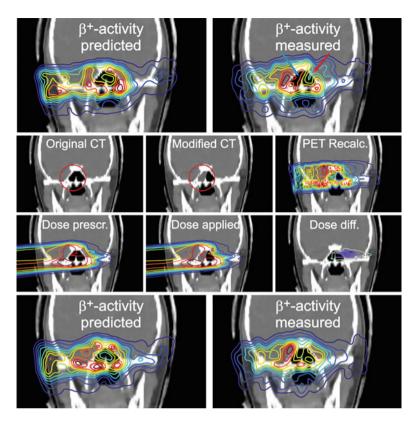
Anatomical changes, their effects on dose and the approximate quantification of dose deviations from the treatment plan. *First row*: Comparison of predicted and measured β^+ -activity. The *blue arrow* indicates a dose deposition in the nasal cavity, the *red arrow* shows missing dose at the distal edge of the irradiation field. *Second row*: on the basis of the assumption of a mucus-filled cavity the planning CT was interactively modified. A fast recalculation of the positron activity confirmed this hypothesis. *Third row*: The difference between the prescribed dose and the dose actually deposited in the tissue recalculated on the basis of the modified CT can be quantified. The maximum deviation is -214 mGy, the maximum dose in this field is 525 mGy. *Fourth row*: Comparison between predicted and measured β^+ -activity 3 days later, after administration of a mucolytic. The nasal cavity is no longer stuffed, the dose is applied as planned
